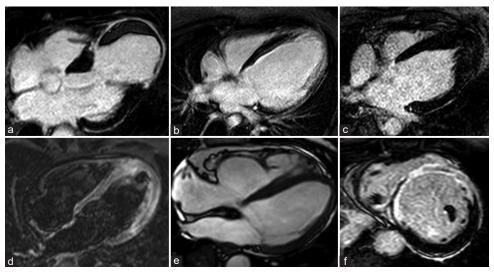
Examples of cardiac magnetic resonance applications in primary prevention: (a) Apical aneurysm of left ventricular with transmural late gadolinium enhancement positivity containing a stratified thrombus after acute myocardial infarction. (b) Diffuse intramyocardial and subepicardial late gadolinium enhancement positivity in a dilated left ventricular consistent with dilated cardiomyopathy. (c) Thickened left ventricular apex with mild late gadolinium enhancement positivity detecting apical hypertrophic cardiomyopathy. (d) Acute myocarditis with subepicardial and intramyocardial edema in a T2-weighted sequence revealing active inflammation. (e) Dilated right ventricular with bulging of the free wall in a patient with arrhythmogenic right ventricular dysplasia. (f) Transmural late gadolinium enhancement of the interventricular septum disclosing sarcoid lesions
